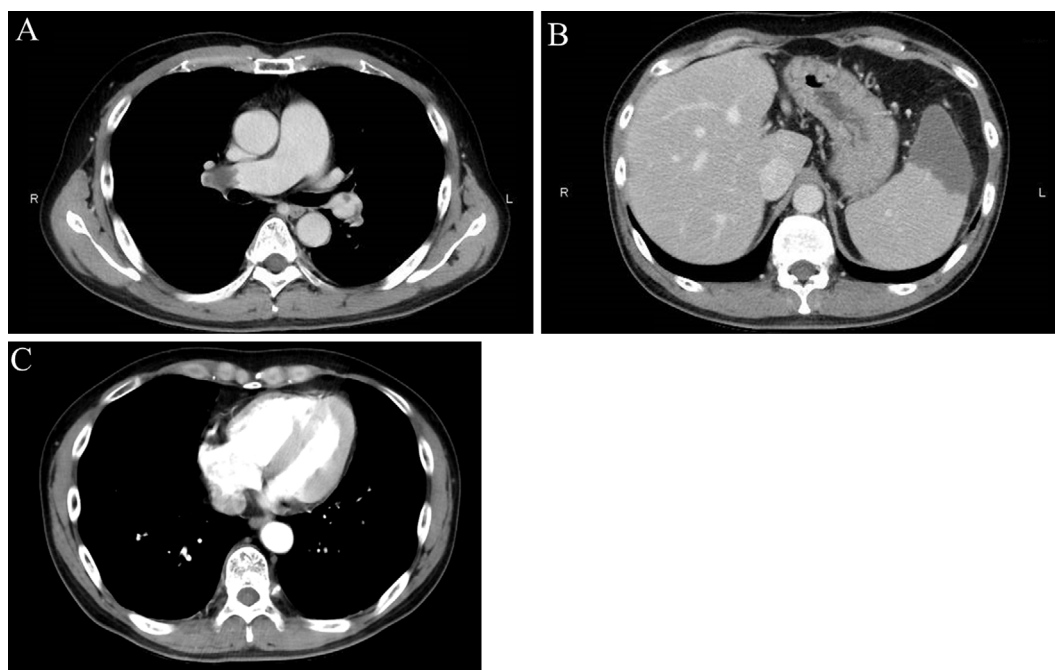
Contrast-enhanced CT for complaints of left abdominal pain and dyspnea. (A) We diagnosed submassive pulmonary embolism. (B) Large splenic infarctions were observed, measuring 7.1 cm×5.0 cm×5.5 cm and 9.0 cm×5.3 cm×8.0 cm at the upper and lower poles of the spleen, respectively. (C) The right ventricle is pushing into the left ventricle, suggesting expansion of the right ventricle.
